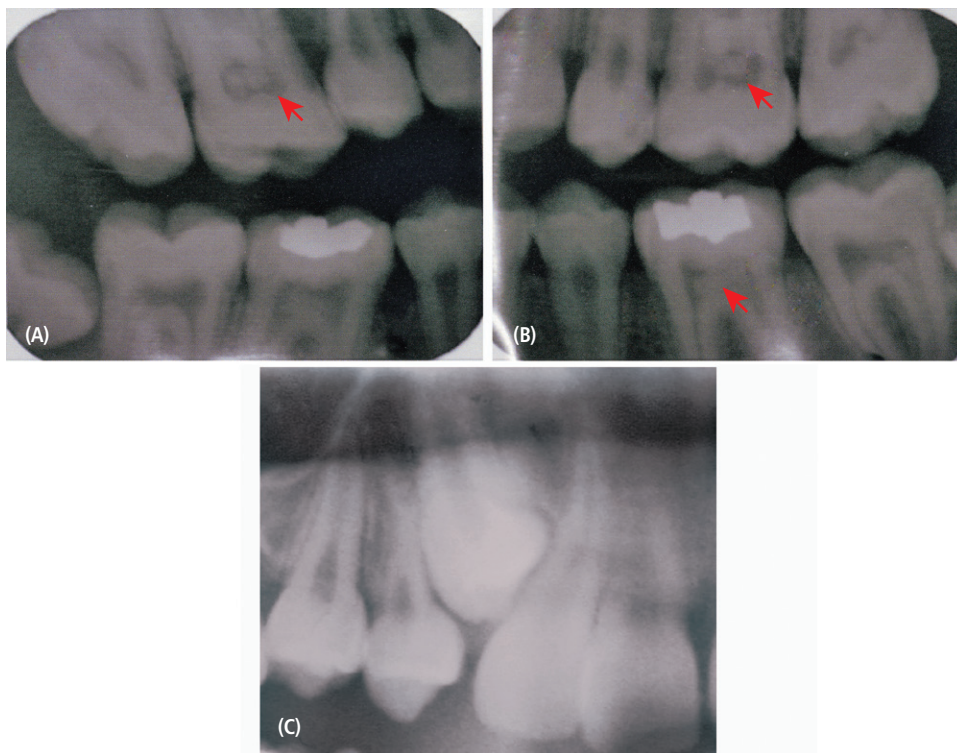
Radiographic presentations of patient HN at 14 years of age. A–B: Note the presence of calcifications in the pulp chambers of the molar teeth. C. Radiograph showing impacted and morphologically deformed tooth 6.
